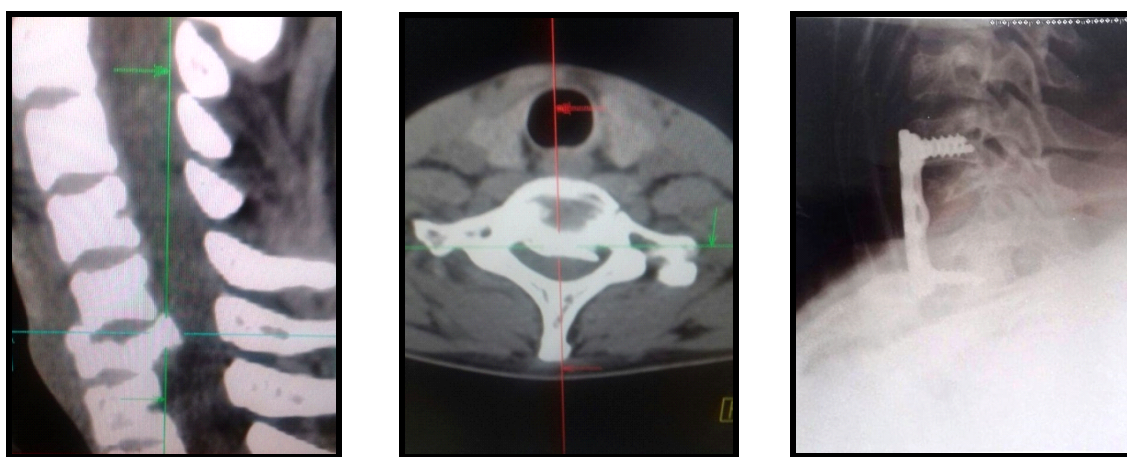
MSCT and X-ray images of the patient before and after surgery.
